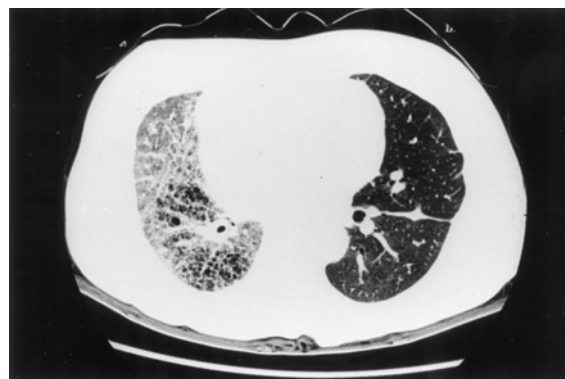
Chest CT scan on POD 91 showing a normal lung field on the left associated with the honeycomb pattern on the native right lung.
